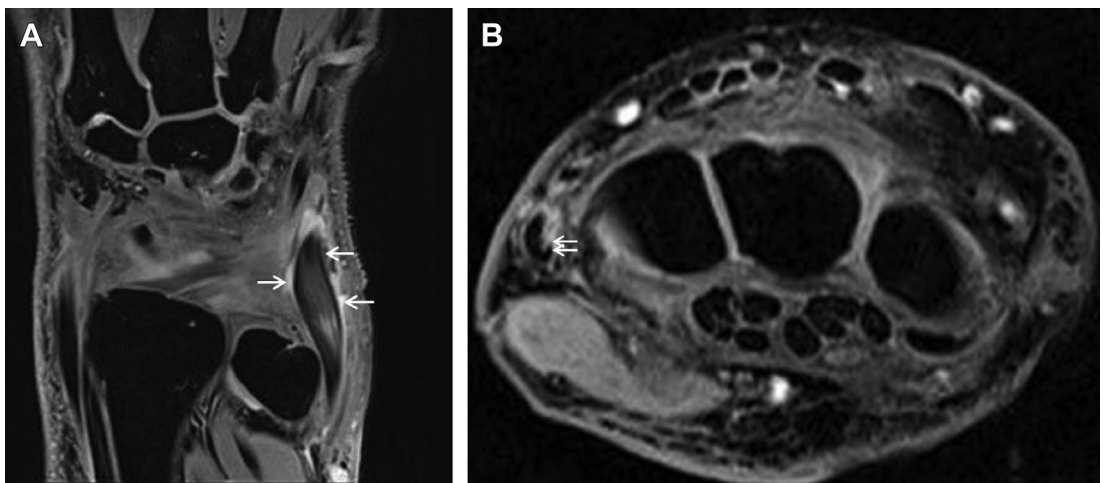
(A) Coronal section of fat-saturated T2-weighted magnetic resonance images of ECU tendinopathy show moderately increased signal intensity at the area of tendinopathy and tendon thickening (*white arrows*). (B) Axial section shows a linear area of high signal intensity within the ECU tendon (*white arrows*) representing a partial tear.
